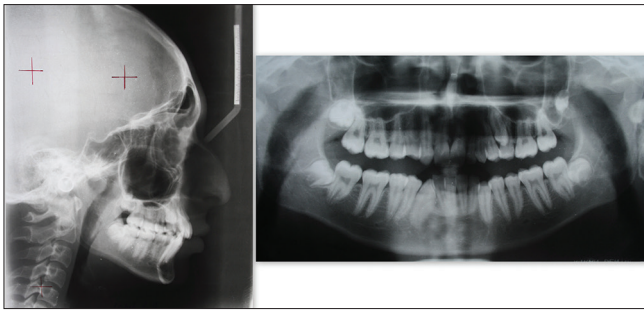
Pretreatment lateral cephalograph and orthopantomogram
